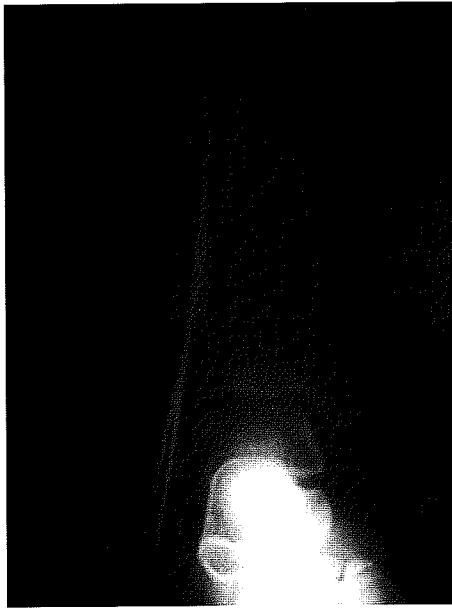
Postoperative radiograph of the ankle.
